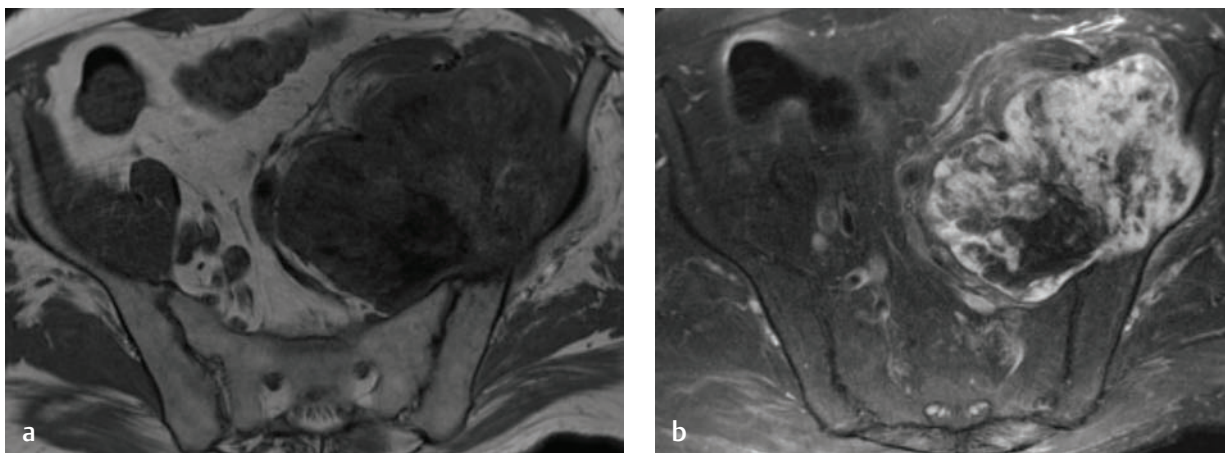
Osteosarcoma. (a) An axial T1-weighted image of a left-side osteosarcoma of the sacrum and ilium. (b) The lesion is hyperintense on an axial postgadolinium, fat-suppressed T1-weighted image with a central hypointense, cystic/necrotic area.
